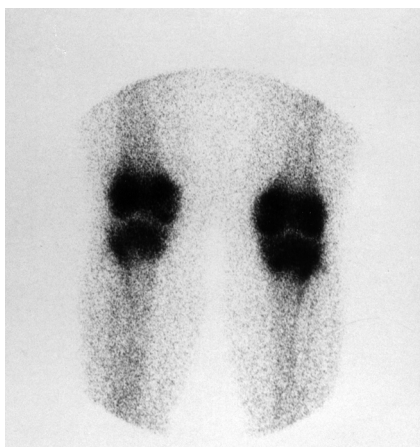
Bone scintigraphy, showing increased uptake in both knees.
